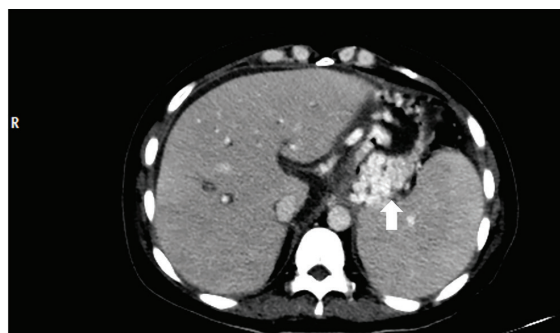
Contrast-enhanced computed tomography (CECT) image demonstrated splenomegaly and fundic varices.
